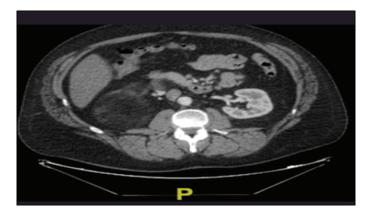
Axial section of the CT Scan showing the right adrenal myelolipoma
